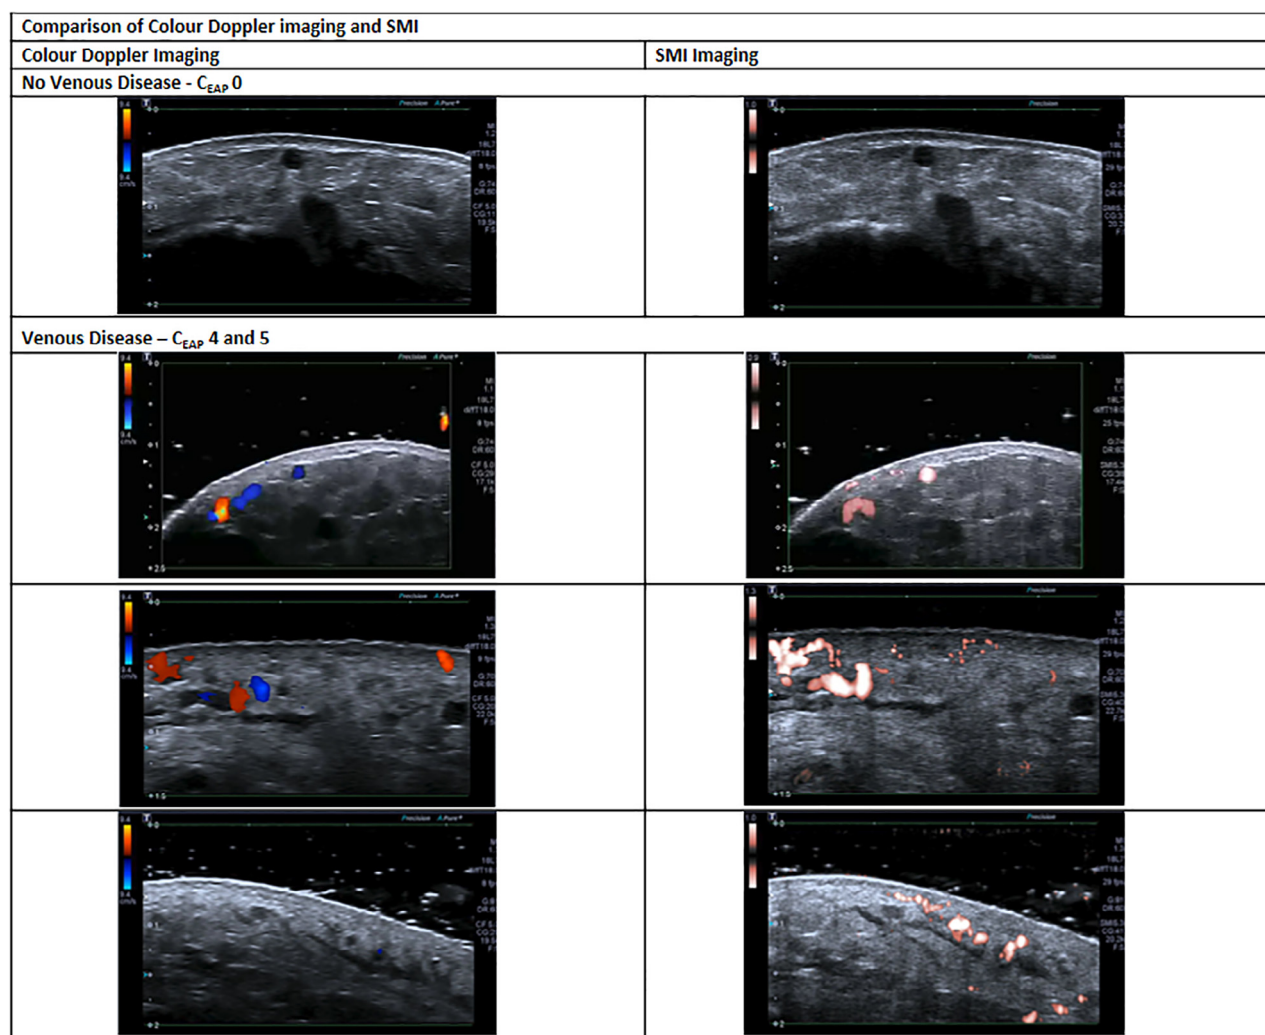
Comparison of colour Doppler imaging and SMI in a control participant without venous disease (*first row*) and three patients with venous disease (*rows 2–4*). SMI, superb microvascular imaging.
